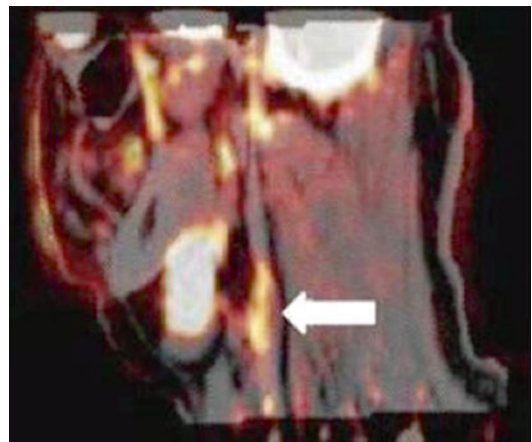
Example of [^{18}F]FDG PET/CT scan in a patient with carotid atherosclerotic lesion in a male patient. *White arrow* show increased [^{18}F]FDG uptake at the level of the plaque in carotid artery (Adapted from Orbay et al. [289])
